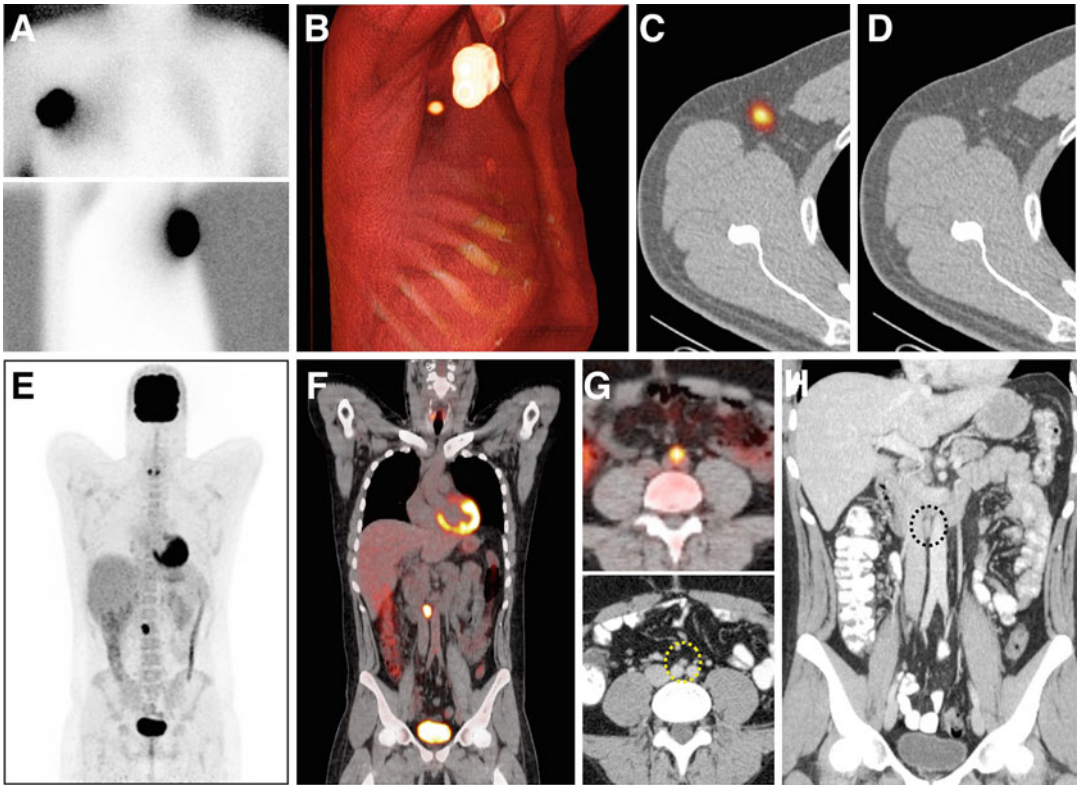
Interventional molecular hybrid imaging leading to radioguided surgery. In *upper row*, planar images show no drainage to the axilla (a), whereas SPECT/CT (b–d) is able to depict an axillary sentinel lymph node near the injection site. In *lower row*, coronal PET (e) and PET/CT
